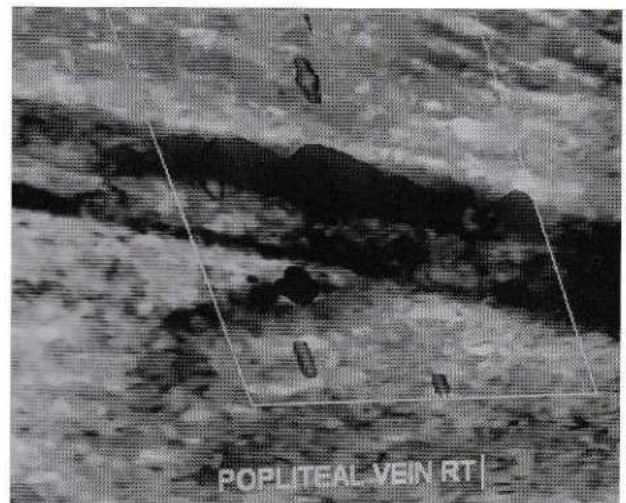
Sonographic image with color Doppler showing hypoechoic thrombus within the popliteal vein with partial occlusion of the lumen .
